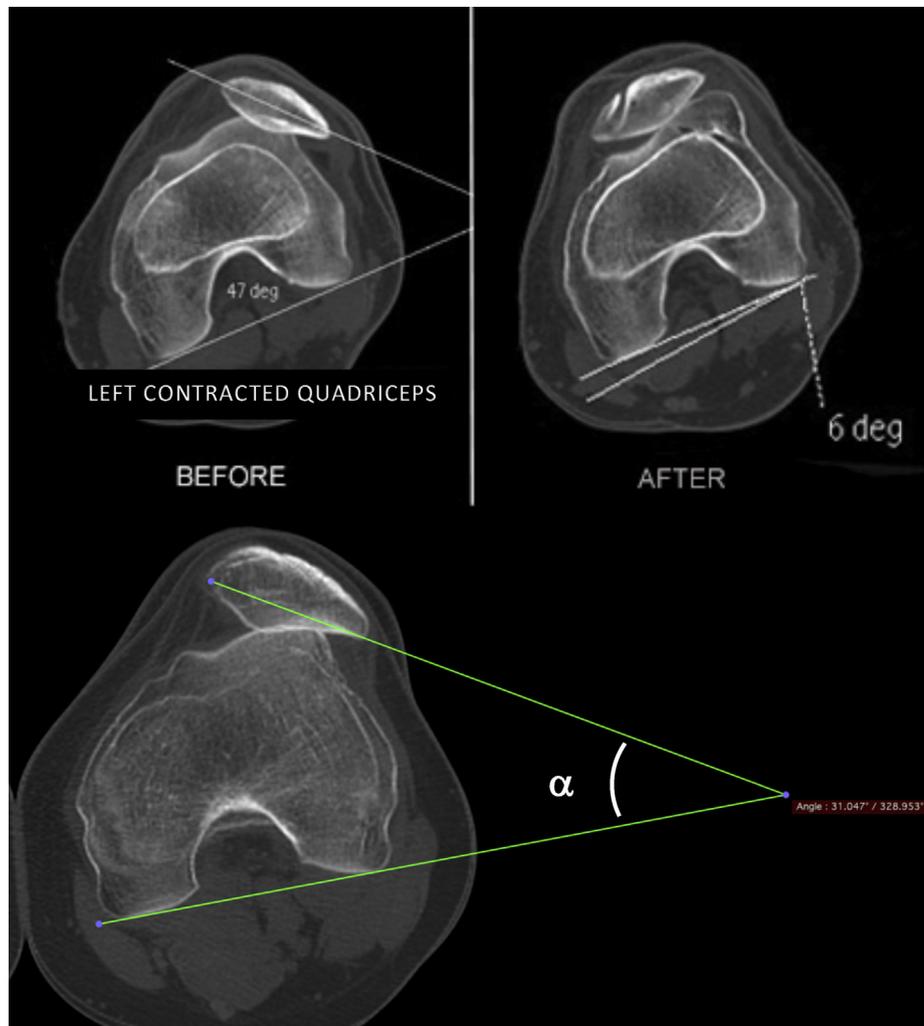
Computed tomography measurement of patellar tilt (alpha: α).
